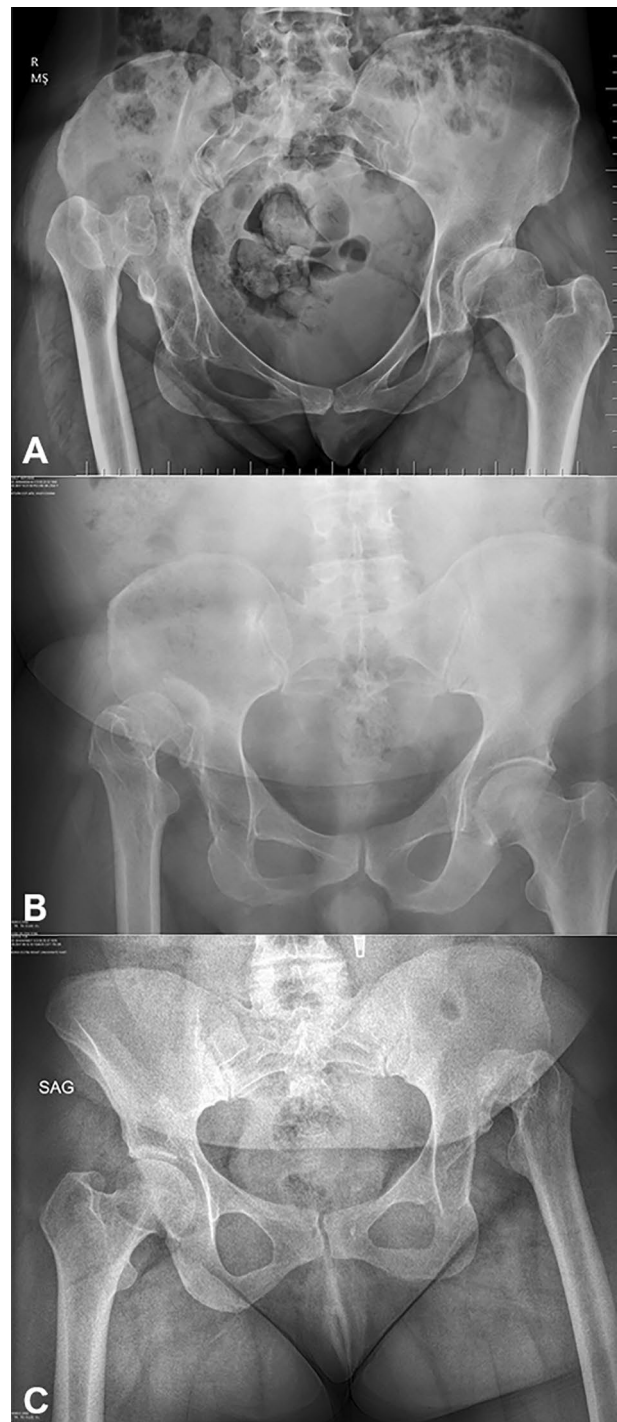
Preoperative anteroposterior hip X-ray of three patients (A, B, C)
